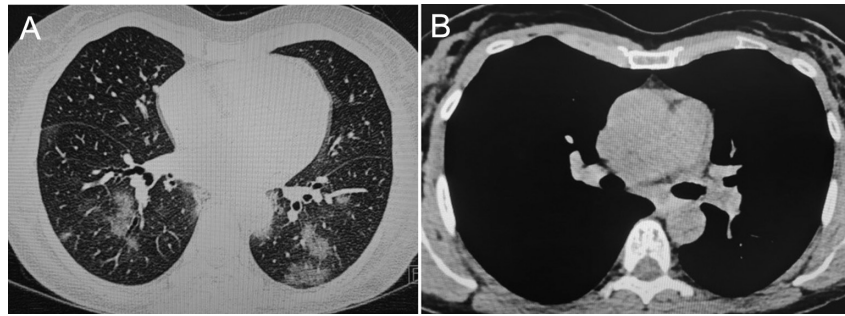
(A) Typical computed tomography (CT) manifestations of coronavirus disease 2019. (B) Initial CT of the mediastinum.
